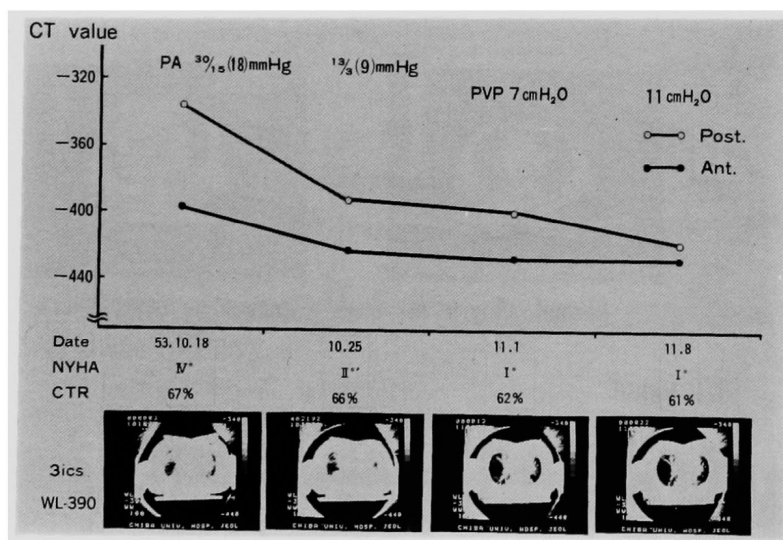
Improvement of CT findings after successful treatment in a patient with acute left ventricular failure due to hypertensive cardiac disease. The mean pulmonary CT value decreased subsequently. Abbreviations: PA=pulmonary arterial pressure; PVP=peripheral venous pressure; Post.=posterior lung field; Ant.=anterior lung field; NYHA=NYHA functional classification; CTR=cardiothoracic ratio.
